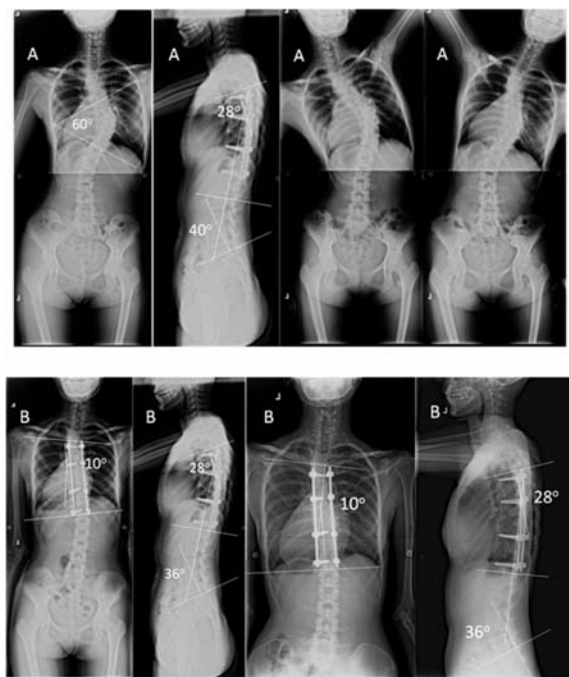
A) Preoperative Standing PA, Lateral, Lateral bending radiographs of a 16 year-old-female with 1AN as Lenke classification. B) The patient underwent posterior correction followed by posterior instrumentation with pedicle screw constructs and posterior fusion from T5 to T12. The major Cobb angle, thoracic kyphosis and lumbar lordosis angle were revealed. C) The major Cobb angle, thoracic kyphosis and lumbar lordosis angle were evaluated at 6 years follow-up. The screw density was 1.14 or 50%.
